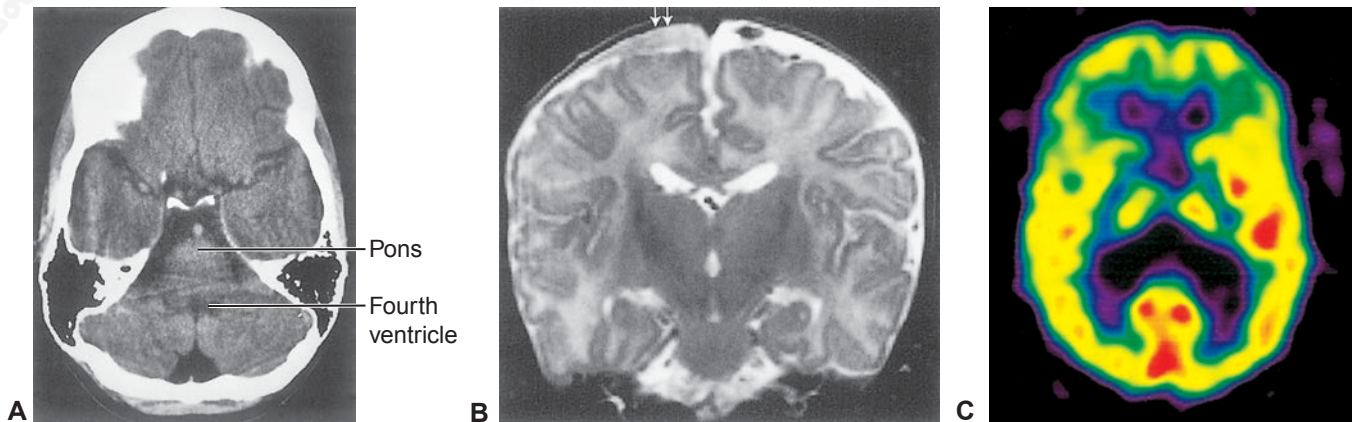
Brain images. A. CT scan of a normal adult brain. B. MRI of the brain showing a subdural hematoma (arrows). C. PET scan showing regions of different metabolic activity.
